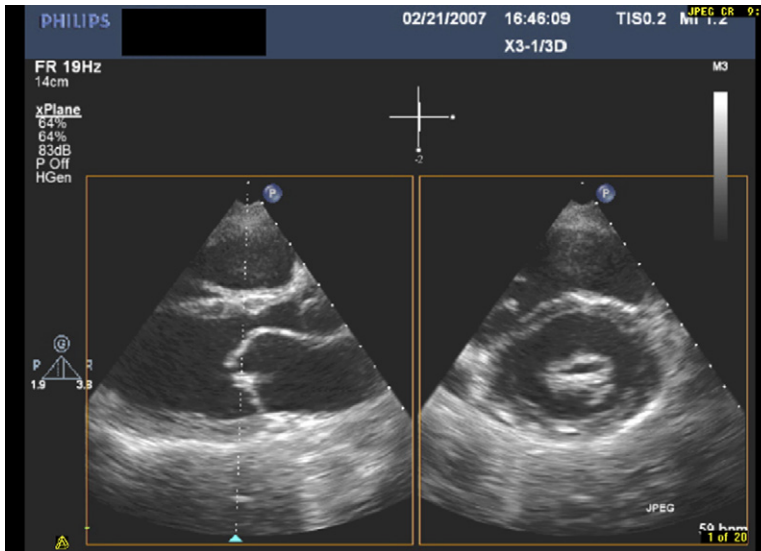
Example of a view of a stenotic mitral valve using biplane 2D imaging. The 3D transducer allows simultaneous display of more than one 2D view. The advantage of this is the ability to confirm that the parasternal short axis view of the mitral orifice is in fact at the tip of the mitral leaflets.
